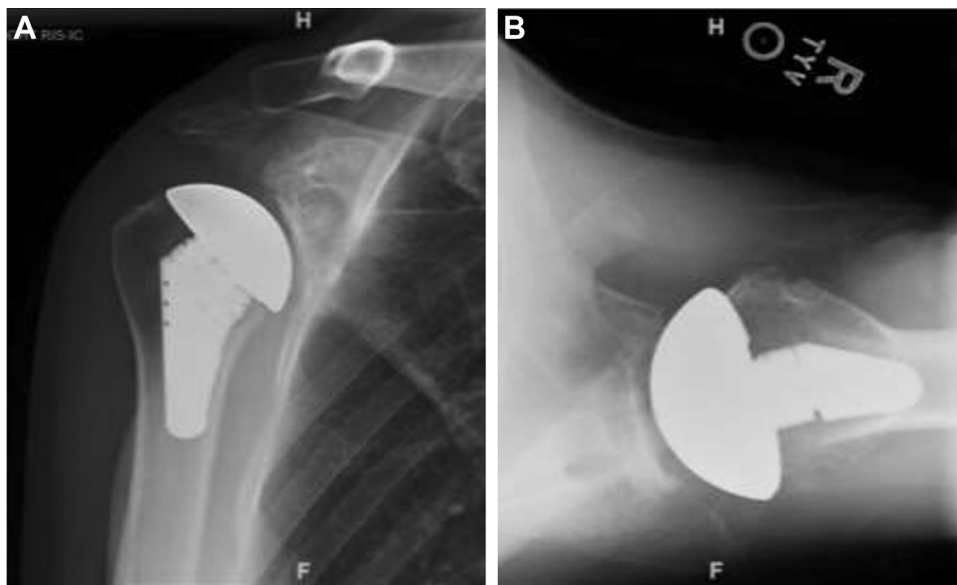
(A) Postoperative true AP X-ray of the *right* shoulder showing total shoulder arthroplasty. (B) Postoperative axillary X-ray of the *right* shoulder showing total shoulder arthroplasty.
